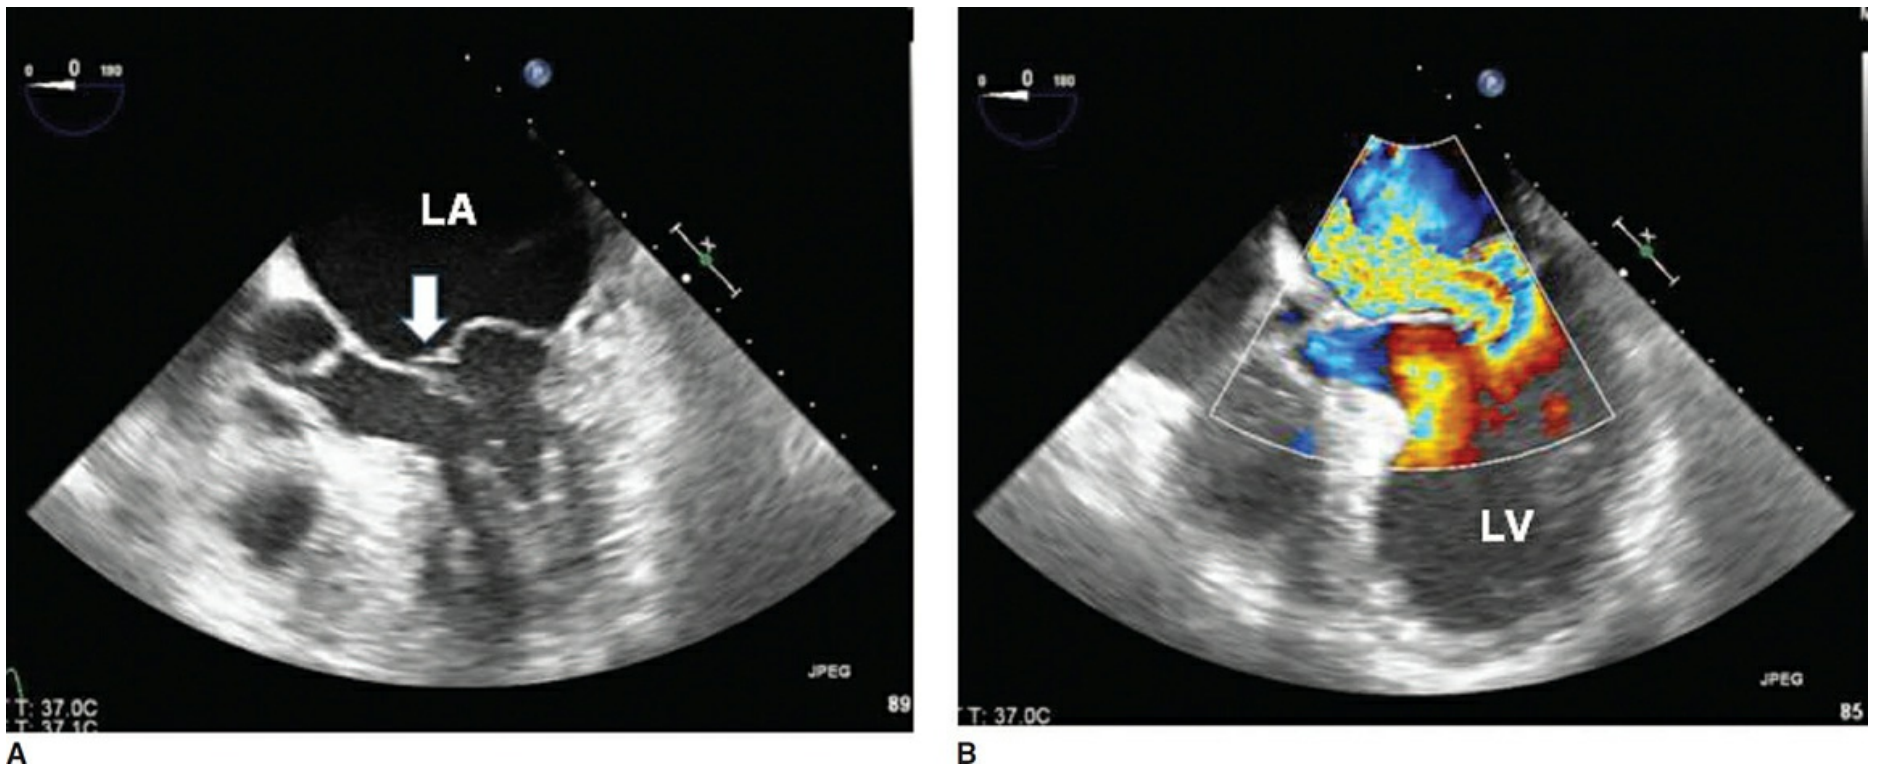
Transesophageal echocardiography image (five-chamber view) demonstrating a flail posterior leaflet of the mitral valve (arrow), and the corresponding color Doppler showing severe mitral regurgitation into the left atrium (LA). LV, left ventricle.
